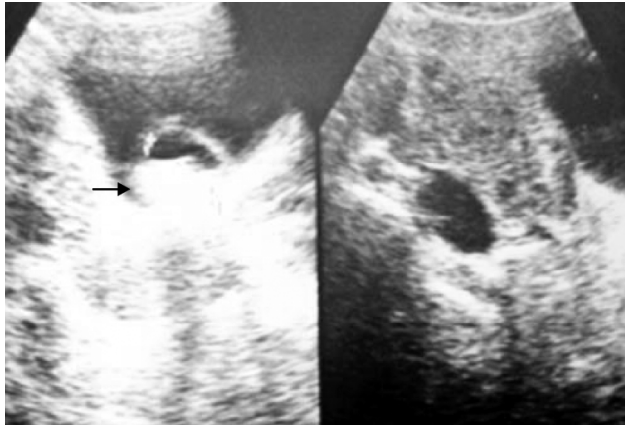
Ultrasonography showing calculi within cyst
